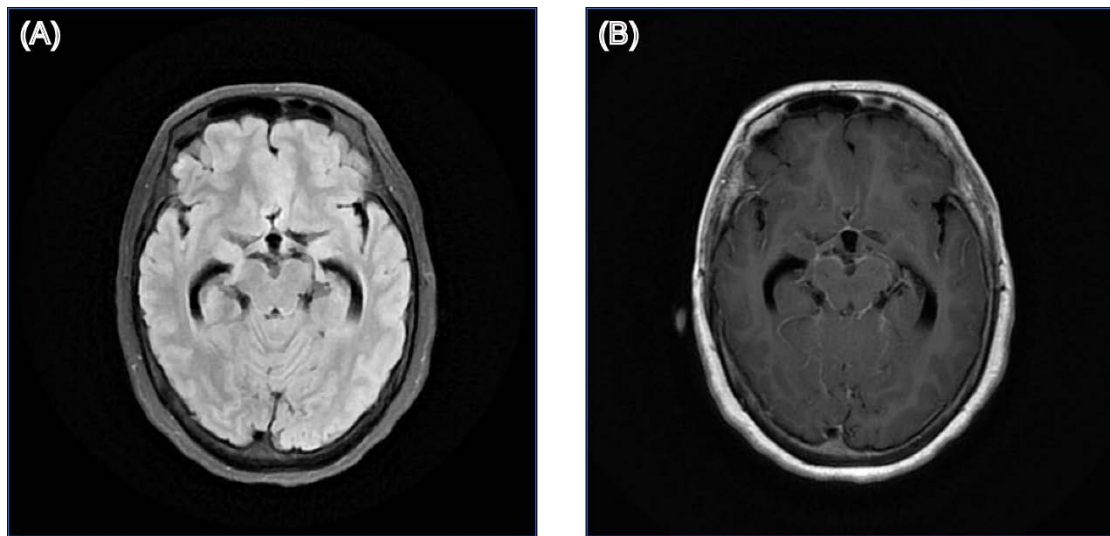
Structural brain MRI images of patient 31. (A) T2-weighted fluid-attenuated inversion recovery (T2-FLAIR) image; (B) Gadolinium-enhanced T1-weighted (Gd-T1w) image.
